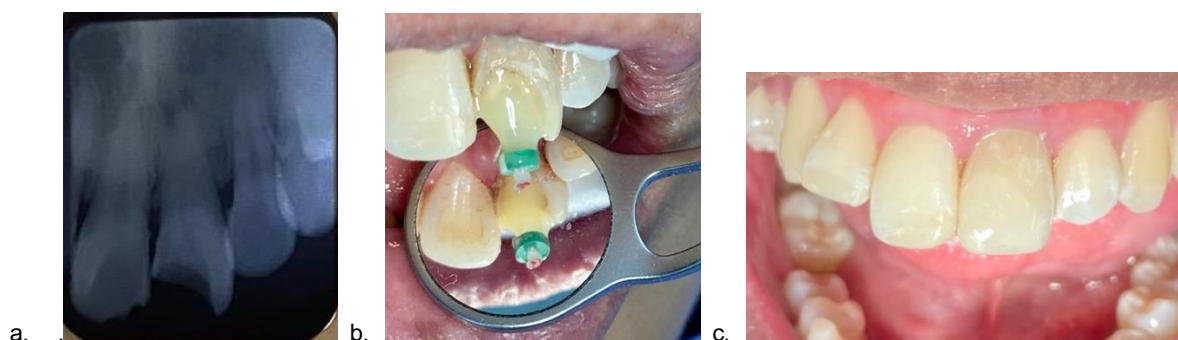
a. Radiograph tooth 21; b. Insertion of fiber post; c. Final restoration of teeth 13,12,1,21.
